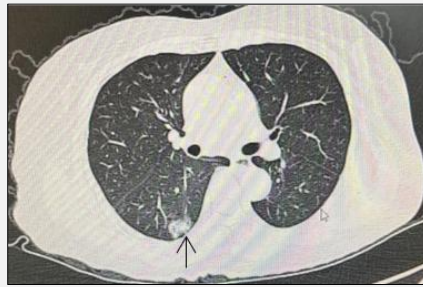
2022-02-03 chest CT suggests patchy hyperdense and solid shadows in the lower lobe of the right lung.
